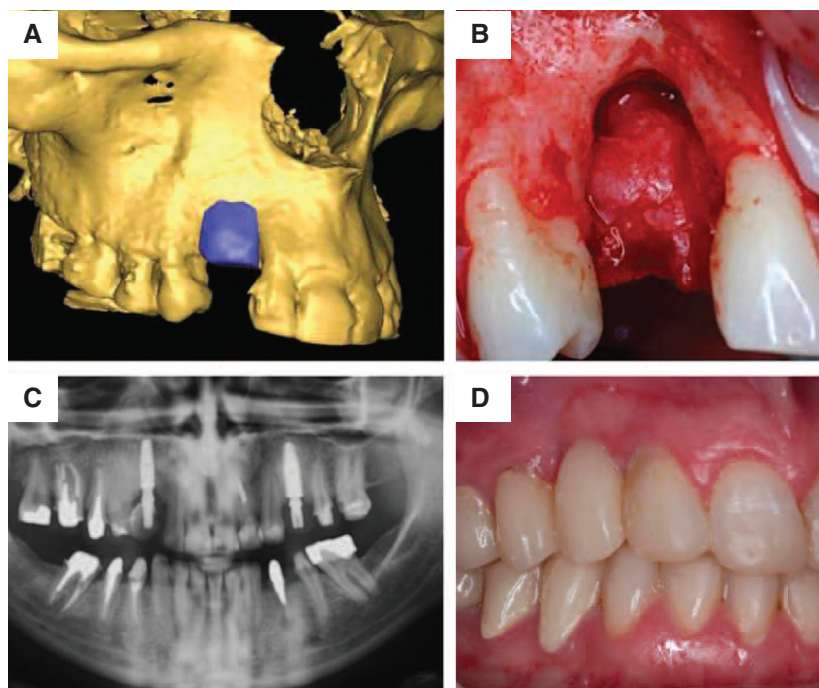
(A) The 3D data of the maxilla, (B) the morphology of the defect, (C) computed tomography image of the maxilla after surgery, and (D) the maxilla after 1 year, without implant loss [86].
